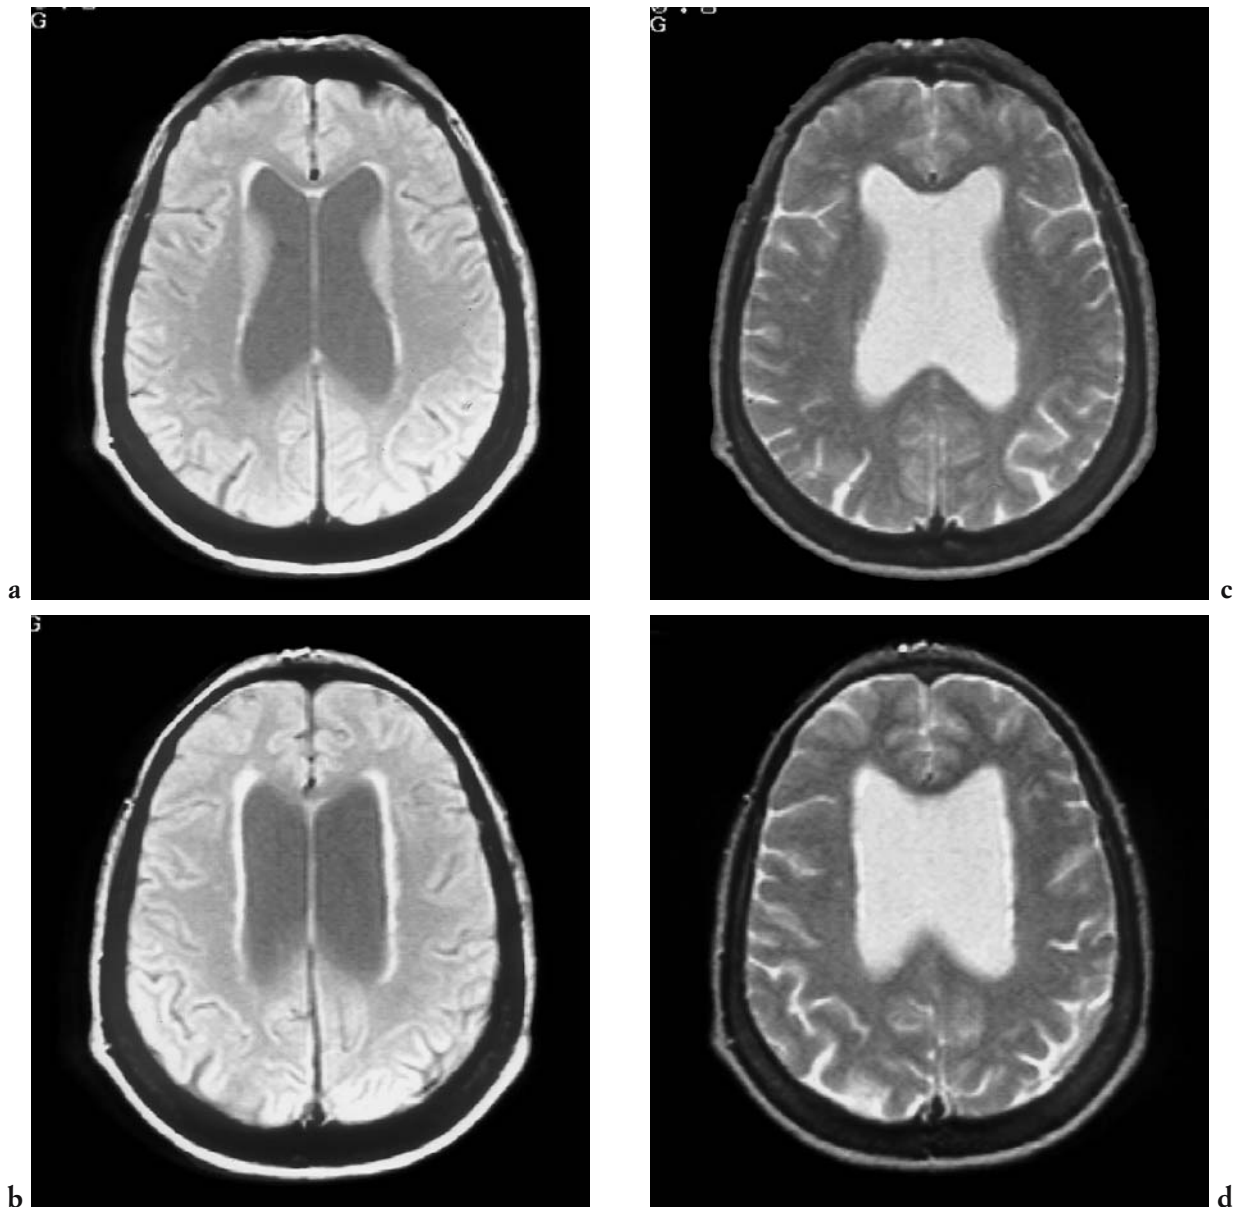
Normotensive communicating hydrocephalus. The MRI images show a thin margin of hyperintensity representing chronic gliosis surrounding the lateral ventricles in a patient with clinically diagnosed chronic normotensive communicating hydrocephalus, not transependymal extravasation of CSF. [a, b) proton density-weighted MRI; c, d) T2-weighted MRI].
